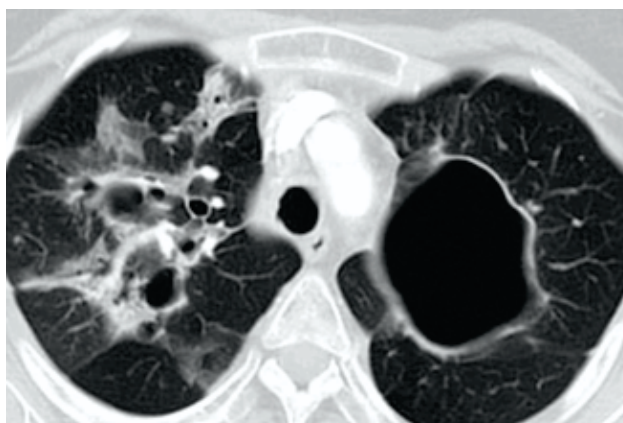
CT scan chest shows multiple cavitary lesions in bilateral lung fields with some patchy areas of ground glass. The largest one in the left upper lobe measures approximately 65 x 58 mm in size.
